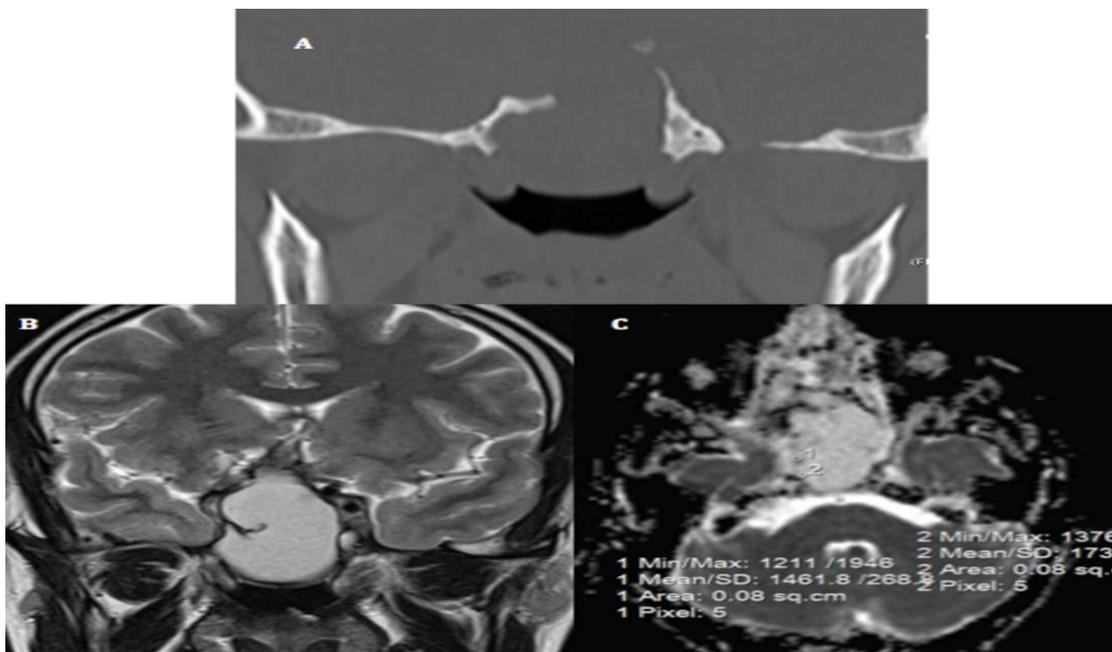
Sphenoid sinus mucocoele. A) Coronal CT and B) Coronal T2WI show large mucocoele filling and expanding the sphenoid sinus associated with destruction of the sphenoidal sinus wall. C) Axial ADC map shows the mean ADC value of the first ROI = 1.4×10^{-3} mm²/s, whereas the mean ADC value of the second ROI = 1.7×10^{-3} mm²/s.
